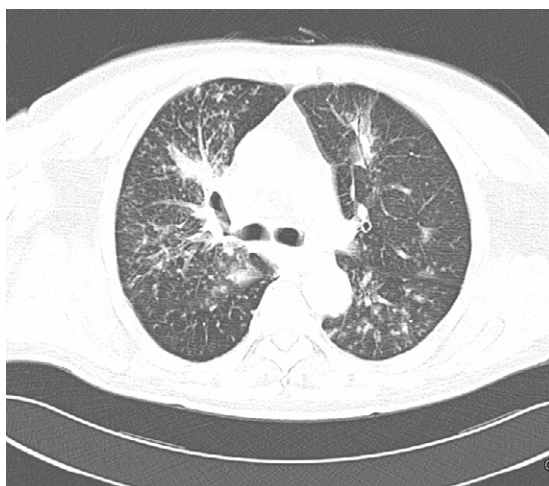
An axial CT scan of the chest, showing posterior wall thickening in the right main bronchus and a decrease in its caliber, as well as irregularities at the emergence of the right upper lobe bronchus.
